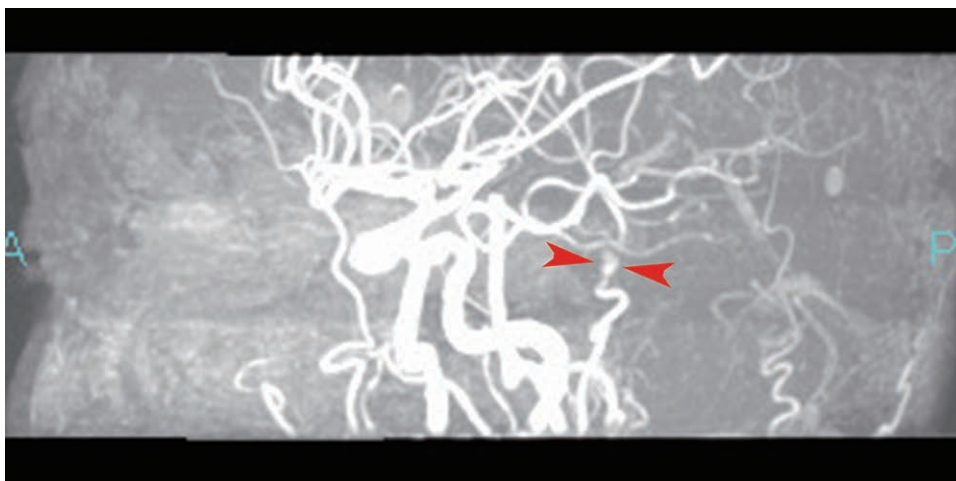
Preoperative enhanced magnetic resonance imaging taken by the previous hospital. The 2 red arrowheads show a pseudoaneurysm in the left STA. A and P indicate the anterior and posterior sides of head, respectively.
